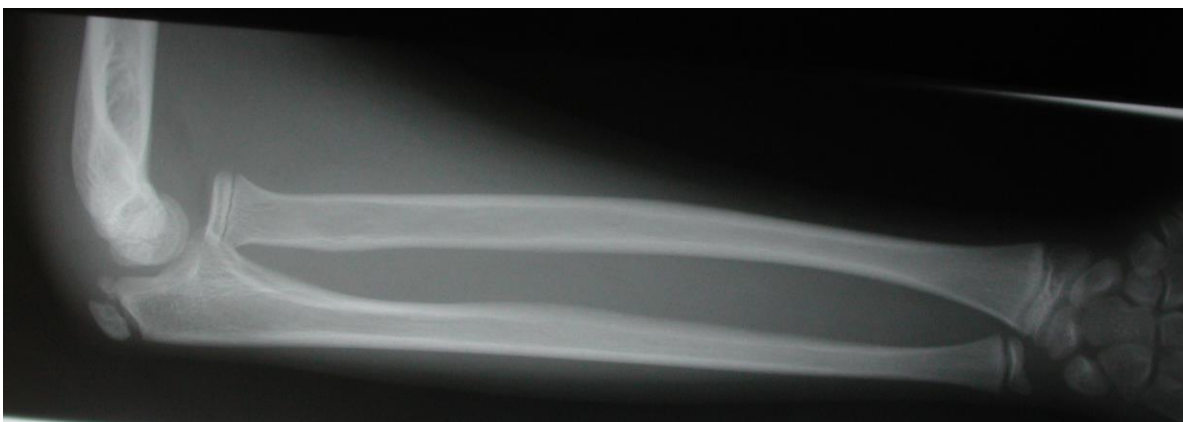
Radiograph of Monteggia Fracture-Dislocation.
